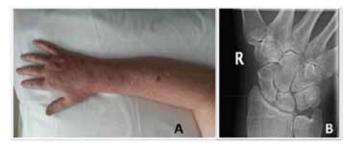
(A) Clinical photograph demonstrating resolution of allergic contact dermatitis, (B) Radiograph demonstration healed scaphoid fracture.
